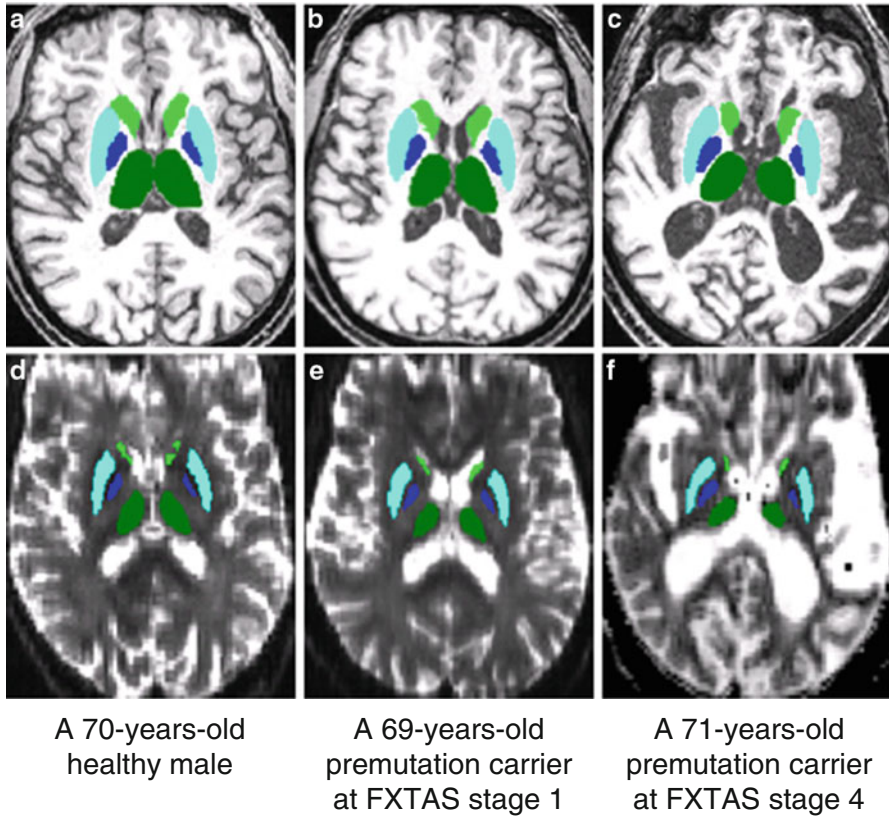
Segmentation of subcortical gray matter. (a–c) T1-weighted images. (d–f) MD maps. *Green*, thalamus; *light green*, caudate nucleus; *light blue*, putamen; *blue*, globus pallidus
